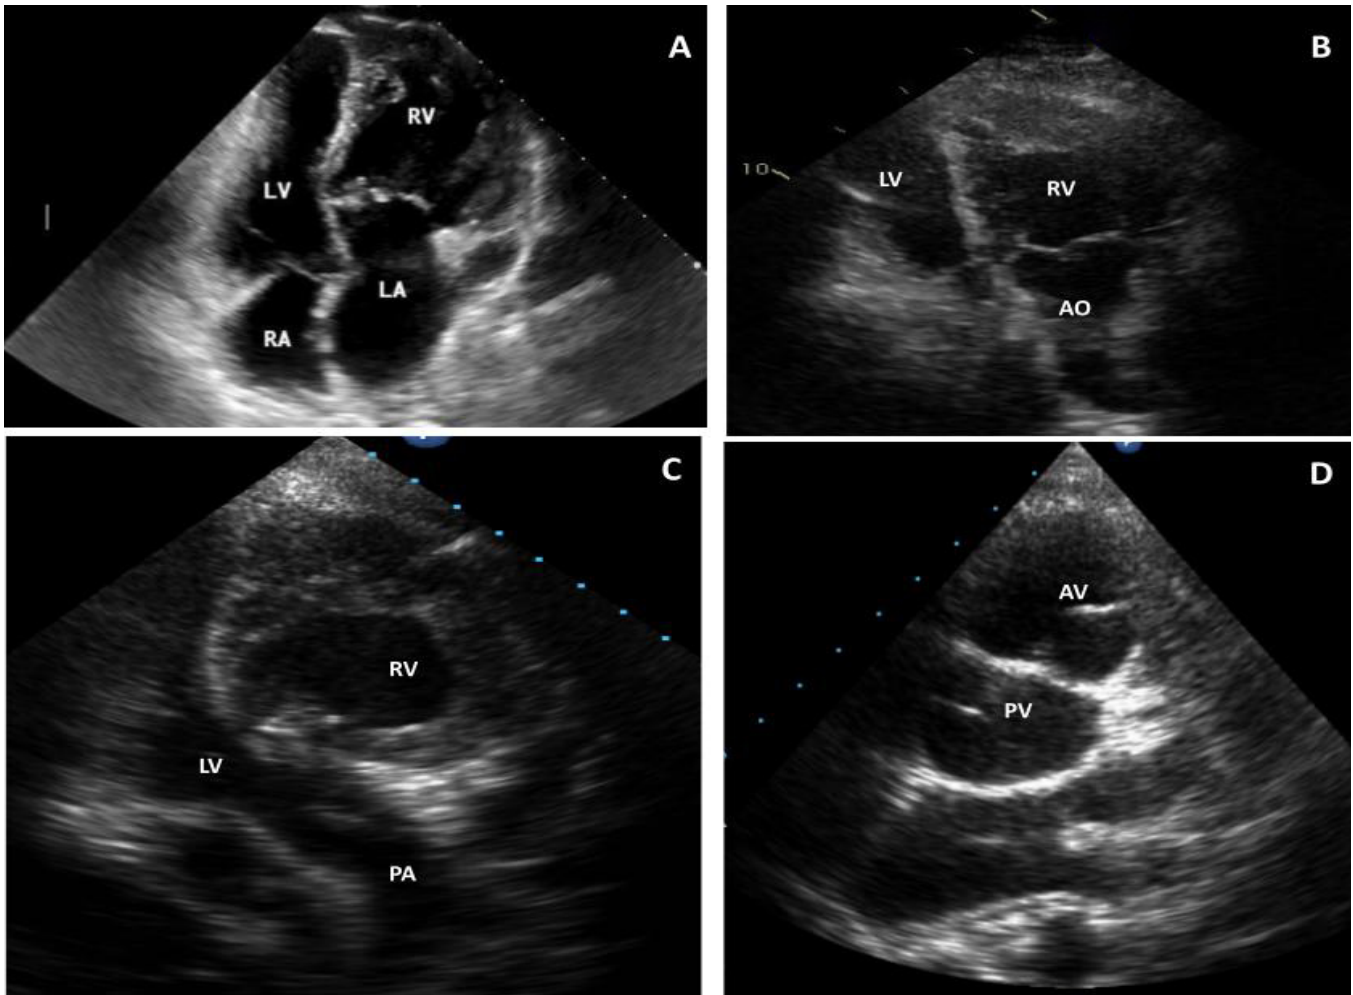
Bidimensional echocardiograms in patients with congenitally corrected transposition of the great arteries. A) 16-year-old patient, four-chamber view. Discordant atrioventricular connections plus moderate tricuspid regurgitation (TR) and mild pulmonary stenosis (PS); B) 35-year-old patient, apical view. Left-sided right ventricle (RV) connected to aorta (AO) plus mild TR/PS after Rastelli operation; C and D) 24-year-old patient with mild TR. Apical view (right-sided left ventricle [LV] connected to pulmonary artery [PA]) (C) and short axis parasternal view (aortic valve [AV] anterior and to the left of pulmonary valve [PV]) (D). LA=left atrium; RA=right atrium.
